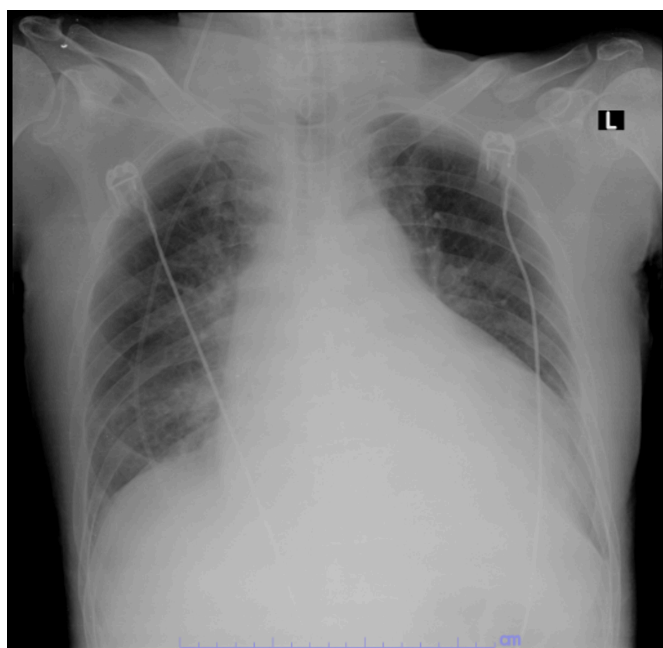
A chest X-ray revealed cardiomegaly with a widening of the mediastinum and haziness at bilateral lung fields.
